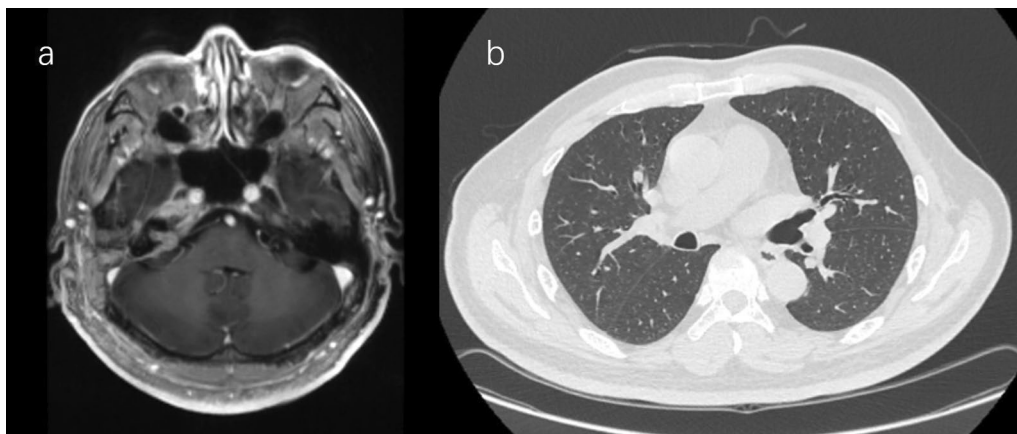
Magnetic resonance imaging suggests tumor recurrence, with nodular shadows along the internal auditory canal showing uniform enhancement post-contrast (a); thoracic computed tomography reveals multiple nodules in both lungs (b)
